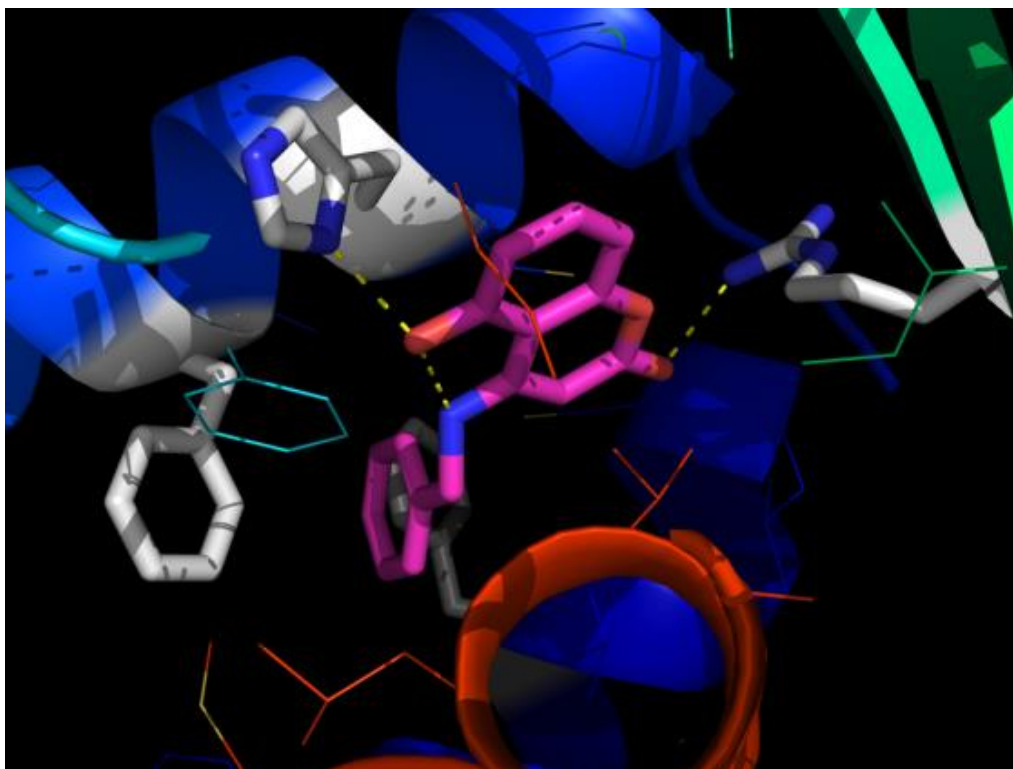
X-ray analysis of compound 81 in complex with *PfDHODH* (unpublished).
